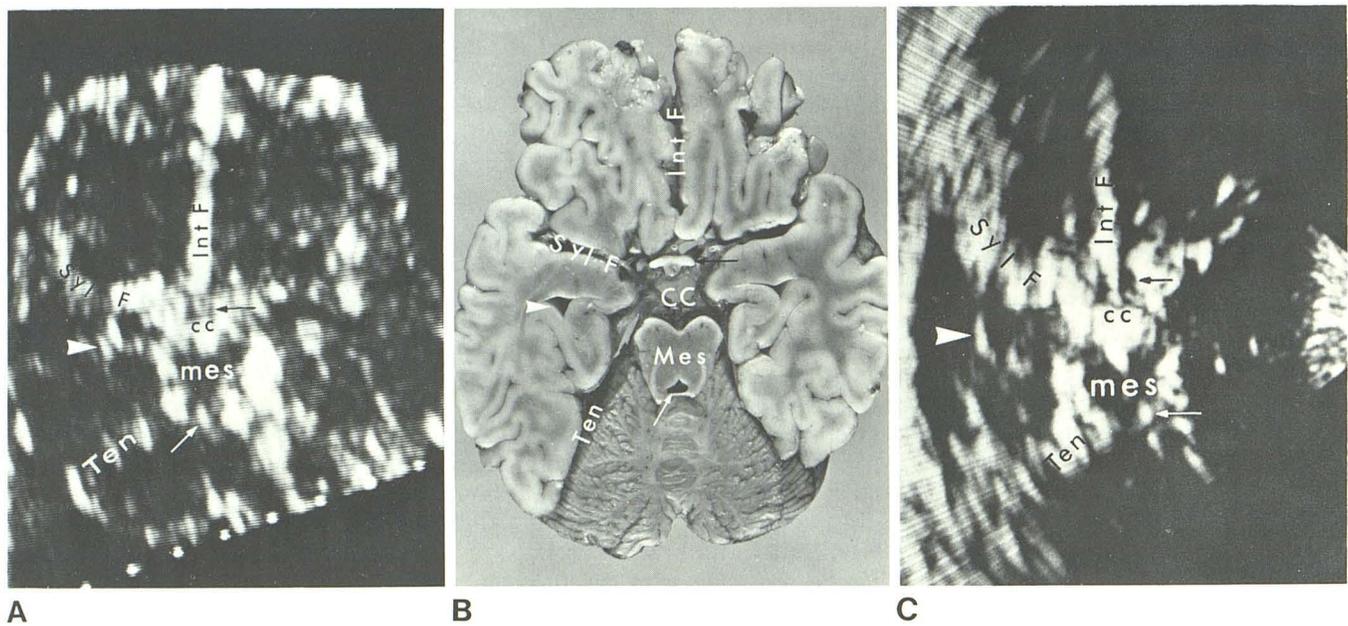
Horizontal plane at level of chiasmatic cistern. A, In vitro real-time sonogram. B, Anatomic section. C, In vivo. CC = chiasmatic cistern; Int F = interhemispheric fissure; Syl F = Sylvian fissure. Mes = mesencephalon;
